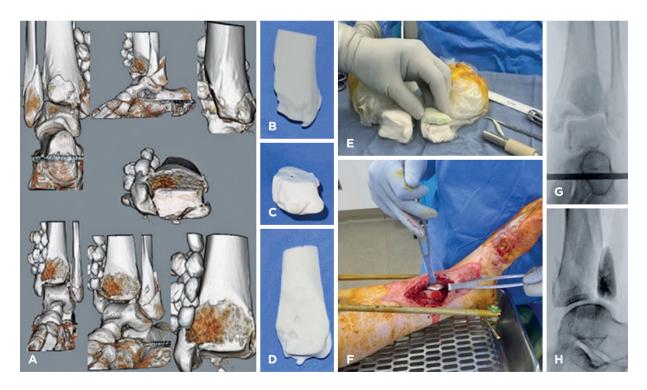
A) 3D CT cuts of the ankle and distal tibia showing distal tibial bone loss and fracture configuration. Note the cement beads on the medial side of the distal tibia B, C, D) 3D printed bone molds. E) The intraoperative clinical photo showing the formation of a cement spacer of the size of the bone defect and fitting it inside the wound. Note that the 3D molds were placed in sterile ultrasound bags. Also, note the right (normal) side mold used to size the spacer in the anteroposterior dimensions. G, H) Intraoperative C-arm radiographs showing properly fitting antibiotic spacer.
